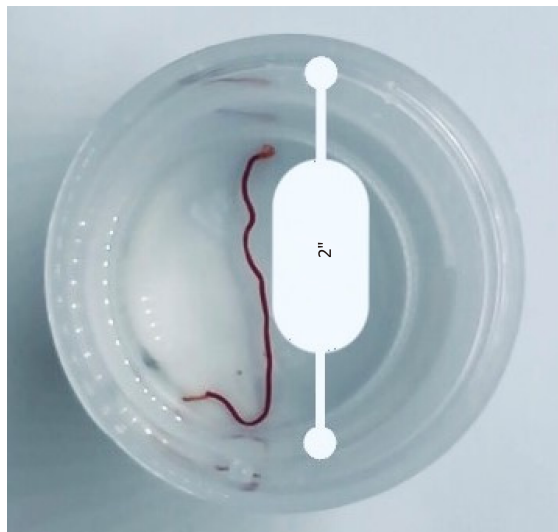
Core biopsy sample obtained via endoscopic ultrasound guided liver biopsy.
